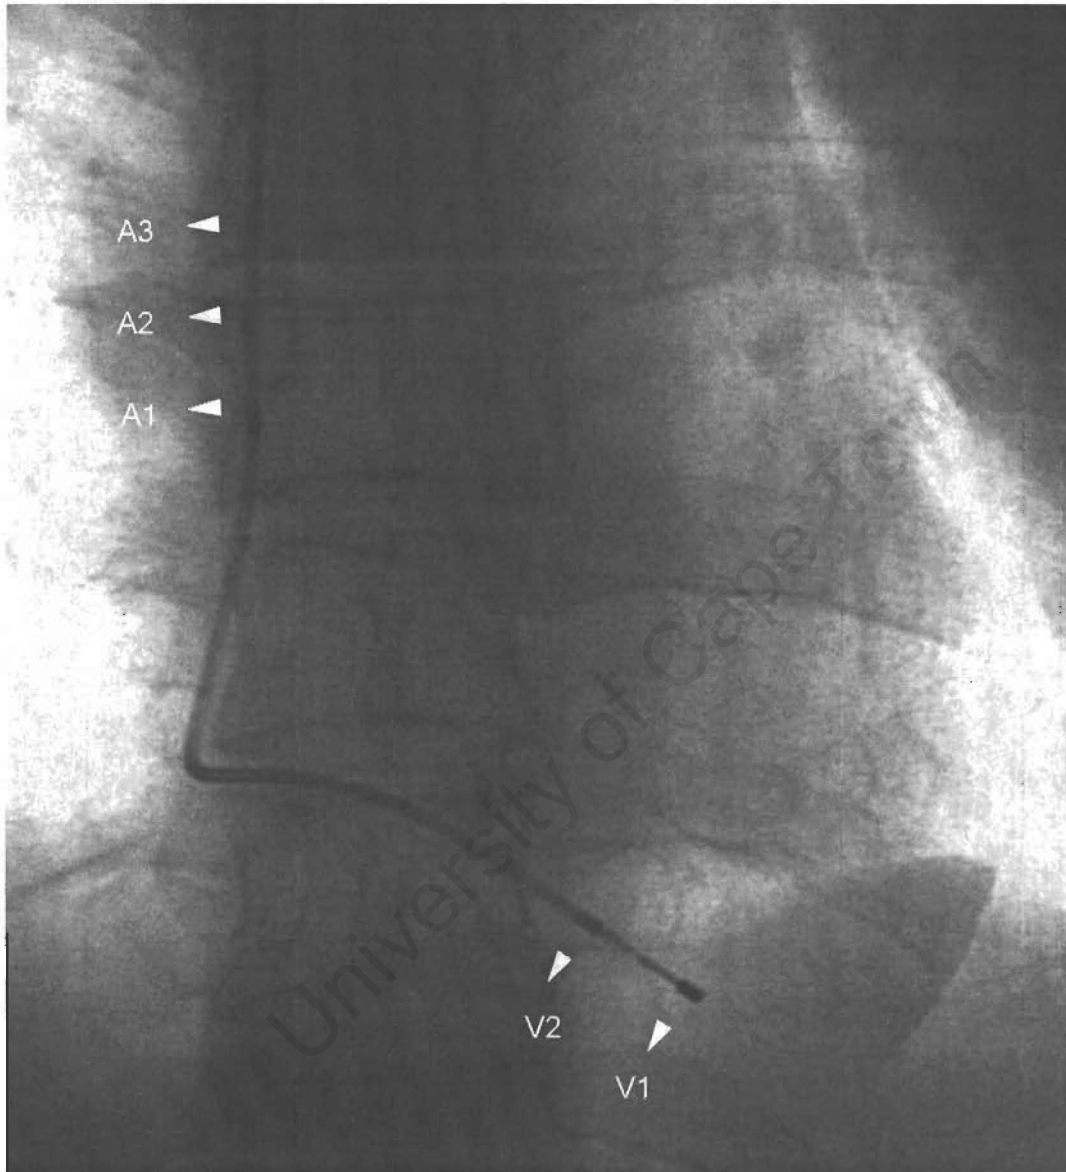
Chest radiograph showing the single-lead catheter in-situ. Note the atrial electrodes (A1, A2 and A3) in the high right atrium.
